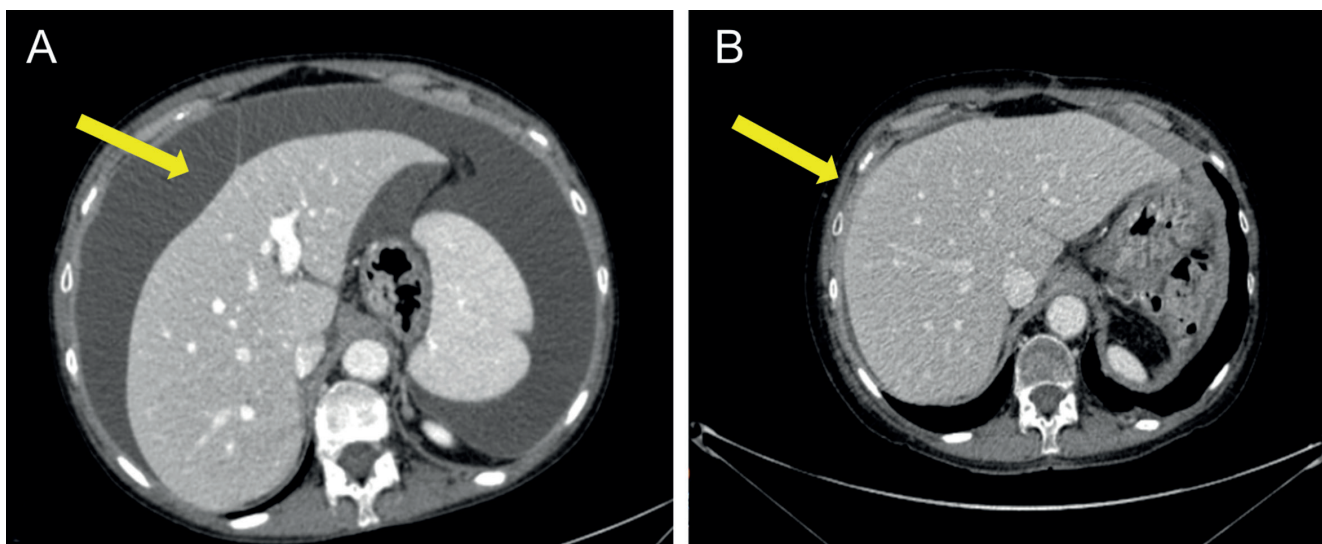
Computed tomography pre (A) and after (B) second-line treatment (achievement of complete radiological response and absence of ascites).
